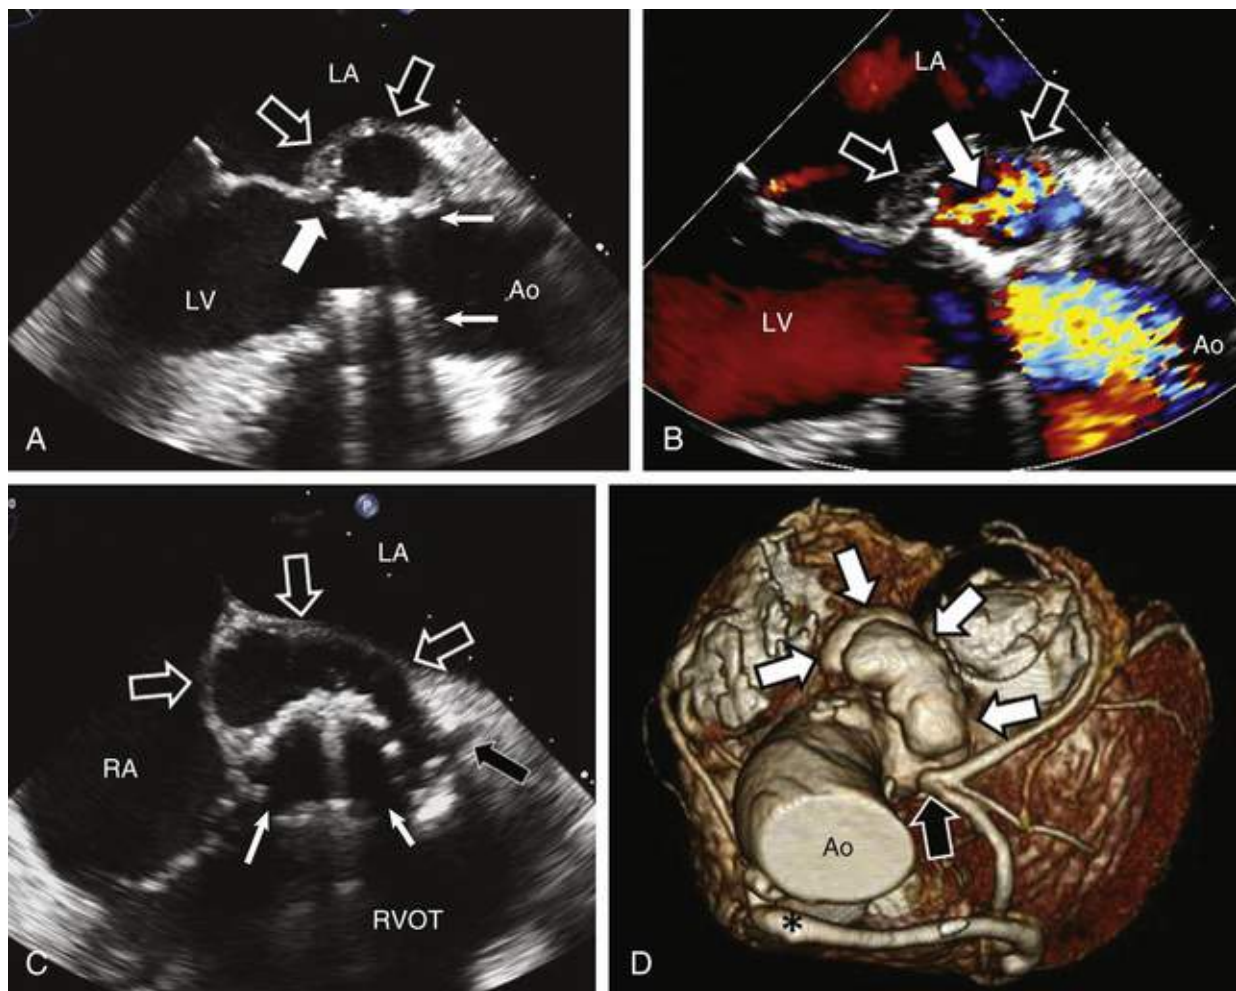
Periannular extension of infection complicating mechanical aortic prosthetic valve endocarditis. A, Transesophageal echocardiography (TEE) image shows a large, mycotic false aneurysm (*open arrows*) within the mitral-aortic intervalvular fibrosa adjacent to the prosthesis (*small arrows*). Communication with the left ventricular outflow tract is evident (*large white arrow*). B, Color Doppler image demonstrates flow communication (*arrow*) into the mycotic false aneurysm (*open arrows*) during systole, at which time the larger, color flow signal exits the aortic prosthesis into the ascending aorta (Ao). C, Short-axis TEE imaging of the mechanical aortic prosthesis (*small arrows*) indicates that the large mycotic false aneurysm (*large open arrows*) extends posteriorly adjacent to the left atrium (LA), bulges toward the right atrium (RA), and extends to the left main coronary artery (*black arrow*). D, Computed tomography with three-dimensional reconstruction, viewed from above and tilted anteriorly to show the posterior aortic root, shows the large posterolateral mycotic false aneurysm (*white arrows*) extending from the aortic root and encroaching upon the left main coronary artery (*black arrow*). A saphenous vein bypass graft (*) to the left anterior descending coronary artery also is seen. LV, Left ventricle; RVOT, right ventricular outflow tract.
